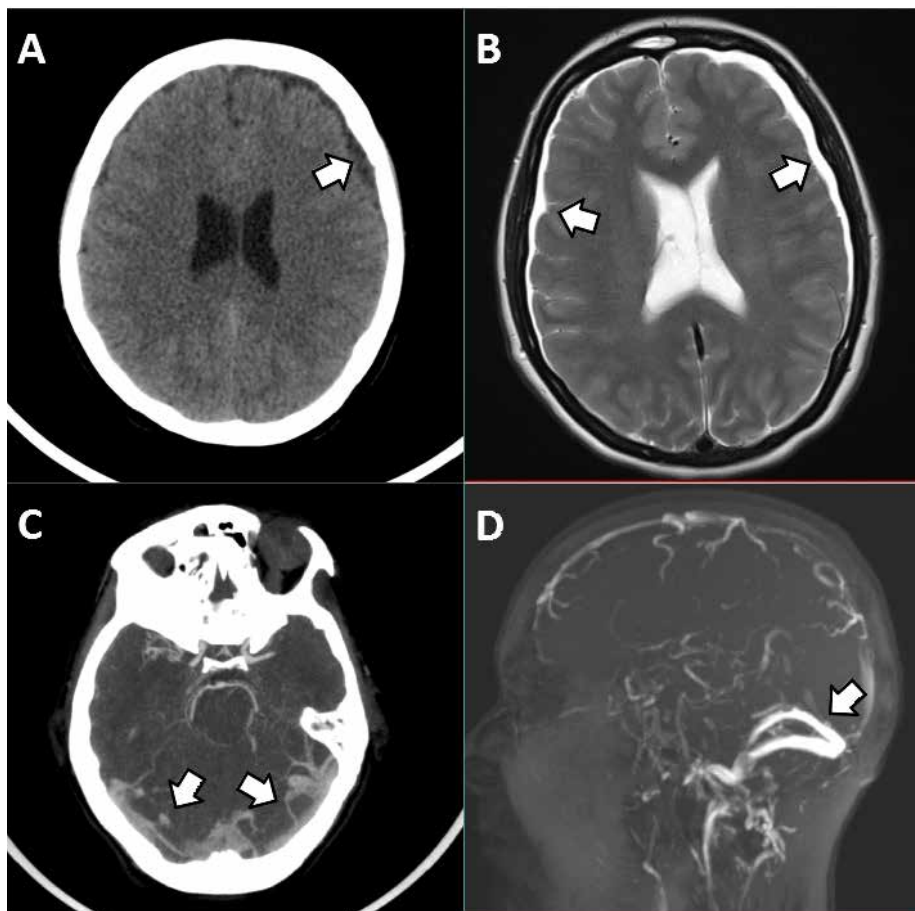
A) CT scan at admission shows initial thickening of the frontal meningeal space (arrow). B) MRI T2 weighted image shows diffuse bilateral meningeal thickening (arrows). C, D) CT C+ and MRI venous TOF angiogram show enlargement of venous transverse sinuses at the skull base (arrows).
